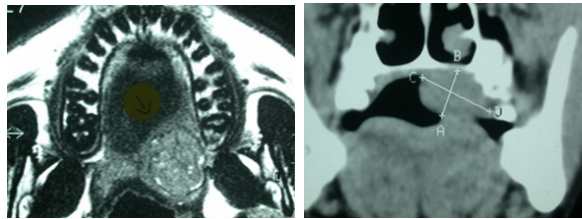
MRI well defined palatal mass
